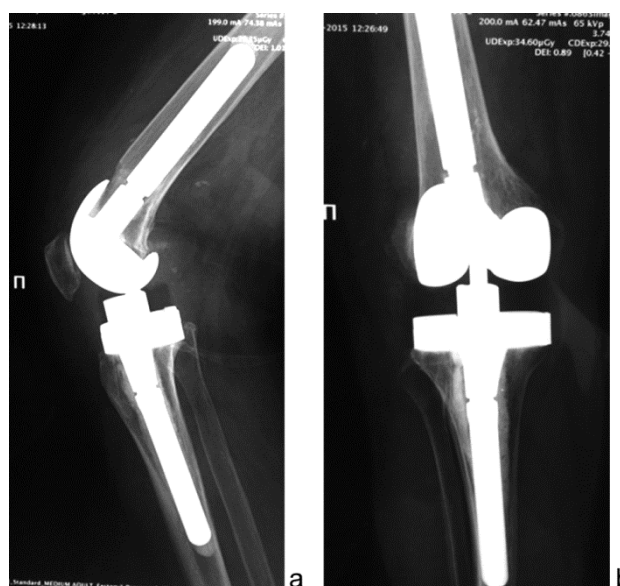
Radiographs of the right knee joint of patient G. six months following revision TKA: a – lateral view; b – AP view
